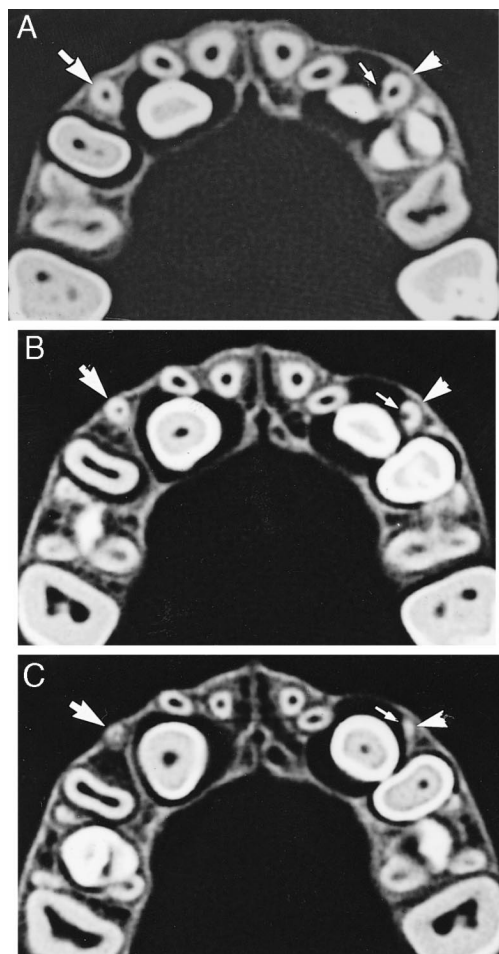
Findings in a 12-years-old girl on axial computed tomography (CT) scans. No. 13 is erupting with mesial inclination and lingually to No. 12. The dental follicle of No. 13 is enlarged and has exposed the roots of No. 12 and No. 11 (A–C) and No. 53 in a small area (A). The periodontal contours facing the follicle are missing. No. 53 (arrows) is unresorbed. The buccal surface of the crown of No. 13 touches the root of No. 12 (A, B). There is no root resorption of No. 12 in the contact area. The root of No. 12 is buccally displaced. No. 23 is erupting distally to No. 22 in an upright position and somewhat lingually within the dental arch (A–C). The dental follicle of No. 23 is enlarged and has exposed the roots of No. 22, No. 24, and No. 63. The periodontal contours facing the follicle are missing. The crown of No. 23 is touching No. 22 and No. 24 but not No. 63. No. 22 and No. 24 are intact. The root of No. 63 has been resorbed in the areas facing the dental follicle of No. 23 but is intact buccally.
